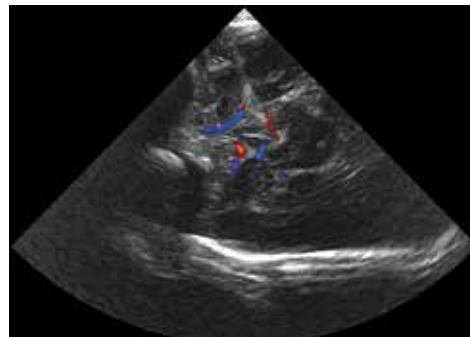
Axial ultrasound scan through the temporal window in preterm infant, showing the brain stem and color flow in the circle of Willis.
